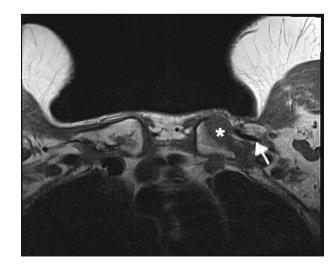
Follow-up MRI of both the clavicles of the patient showing fracture non-union (star) with the formation of pseudoarthrosis (arrow) in axial view.
